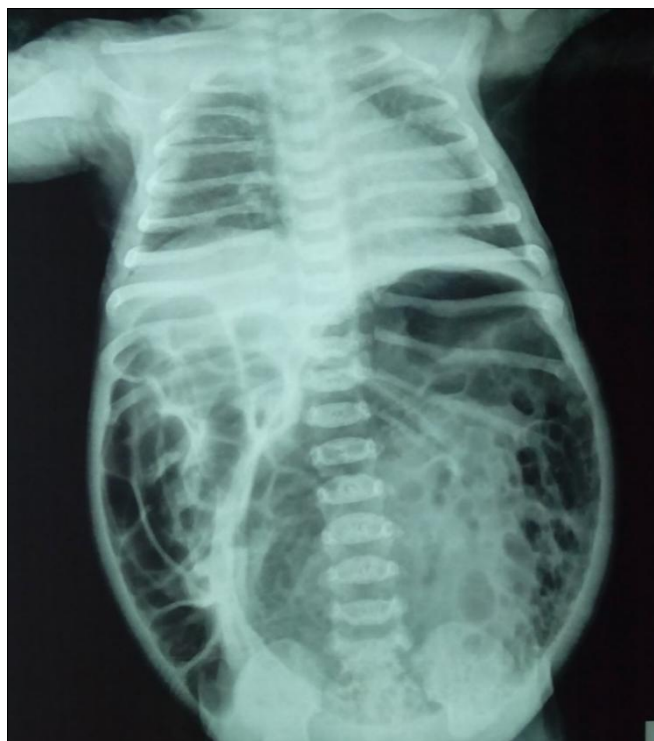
X-ray abdomen and chest
